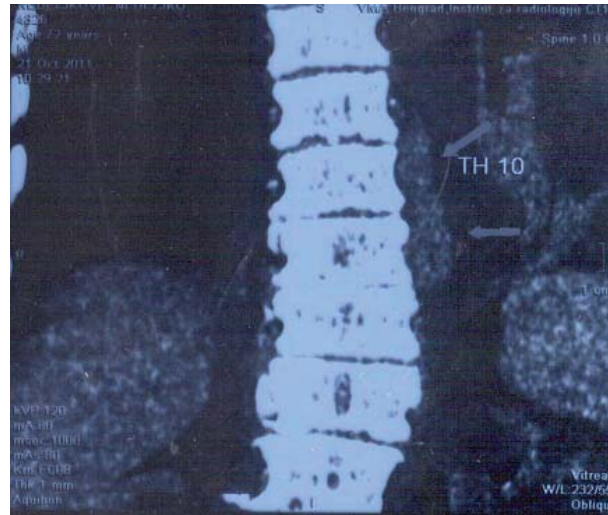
Magnetic resonance imaging – a paravertebral tumor mass.
